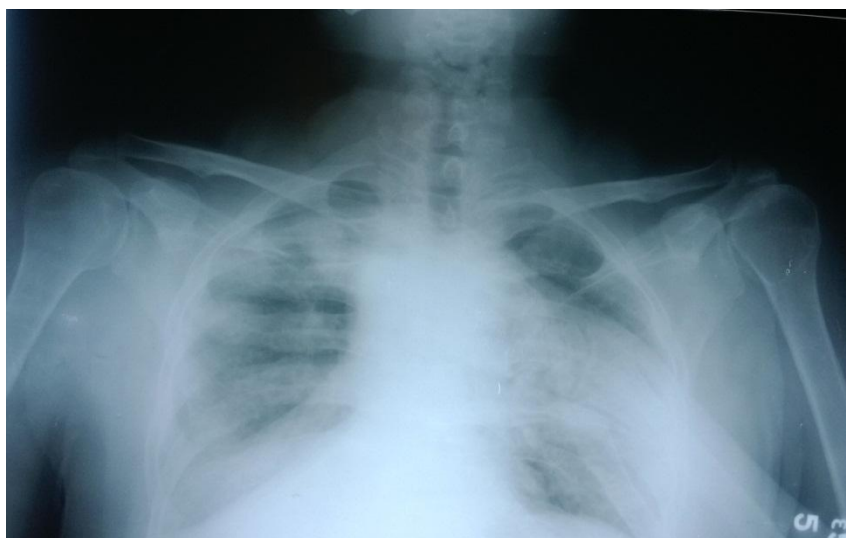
X-ray bilateral shoulder AP view post reduction
